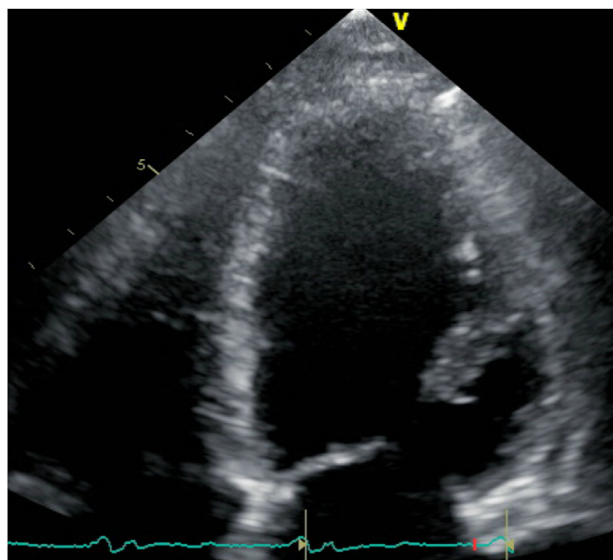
Echocardiogram demonstrating mildly dilated left ventricle with an ejection fraction of 45%.
